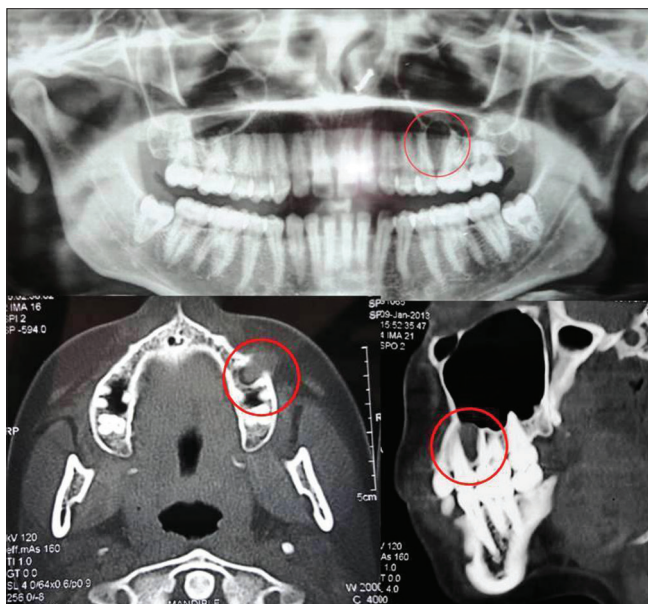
Optic pathway gliomas and computed tomography of Case 2
